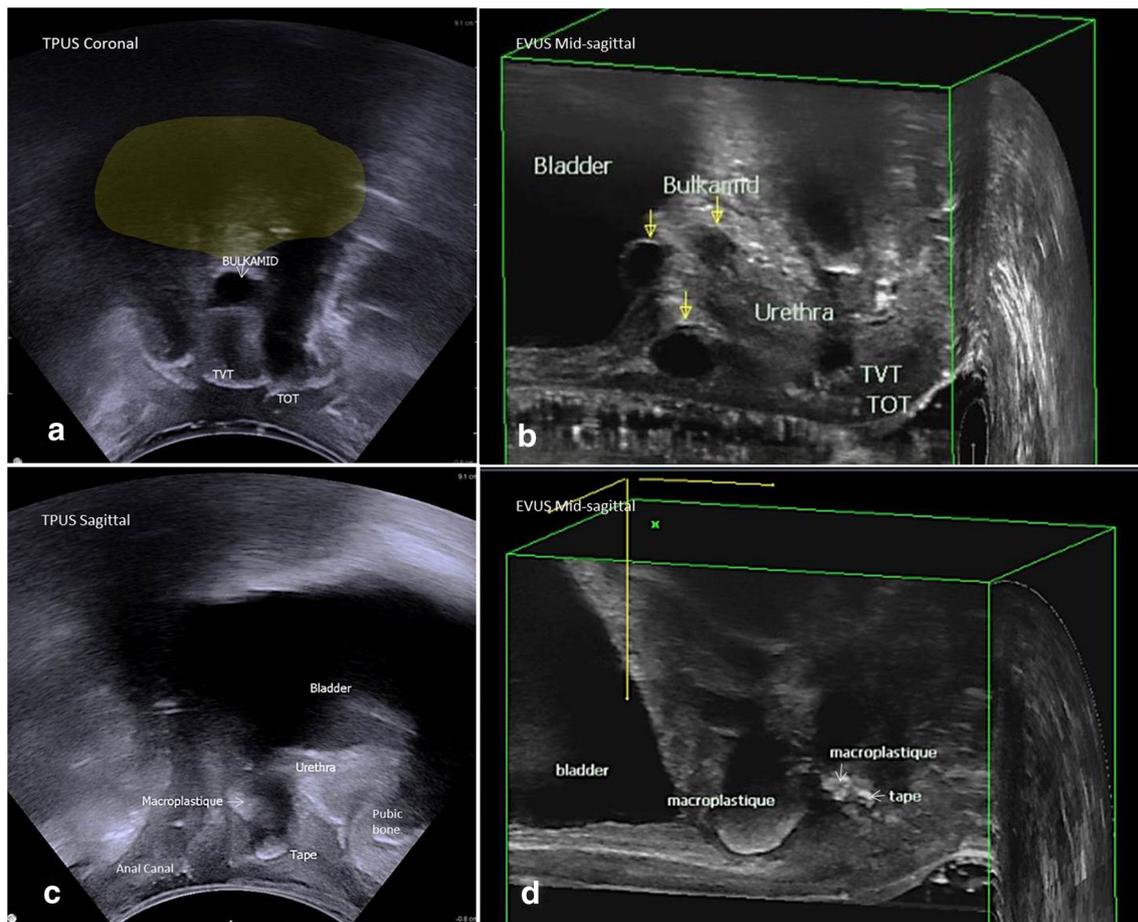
Urethral bulking agents. a Perineal pelvic floor ultrasound coronal view showing Bulkamid® as a hypoechoic area by the bladder neck as labelled (bladder highlighted in yellow). This patient presented with de novo urgency and reported to have undergone a transobturator tape (TOT) insertion that was partially excised owing to voiding dysfunction, followed by a tension-free vaginal tape (TVT) insertion (as labelled). Evidence of material used for Bulkamid® injections was also seen (unknown to the patient). b Mid-sagittal view on endovaginal ultrasound of the anterior compartment demonstrating the bulking agent (arrows) bulging into the bladder and bladder neck. The two MUSs can also be seen at
